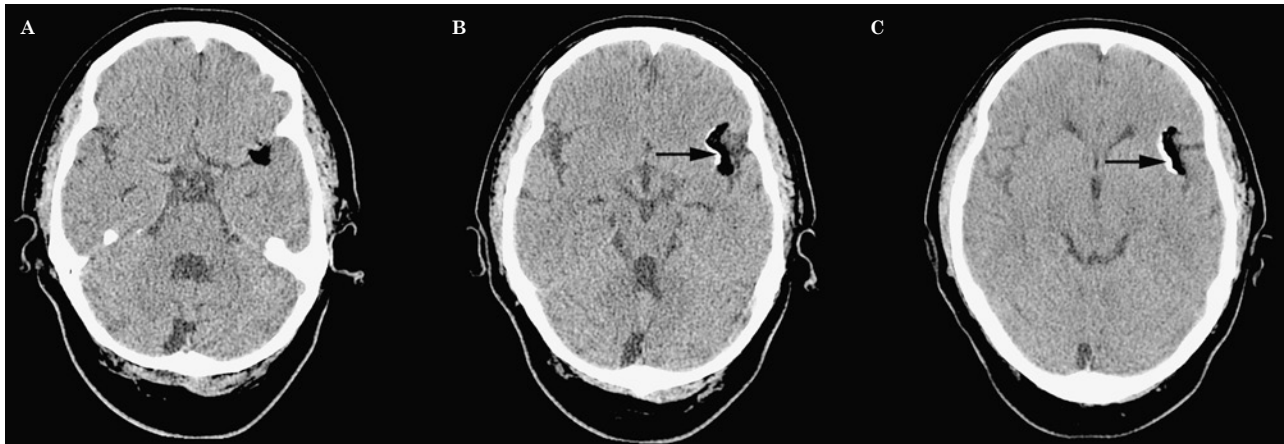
Lipoma. Axial noncontrast CT images reveal a well delineated lobulated extra-axial mass with fat attenuation (mean HU = -77) within the left sylvian fissure (A-C). 'Eggshell' calcification (arrows) is noted along its medial border.
